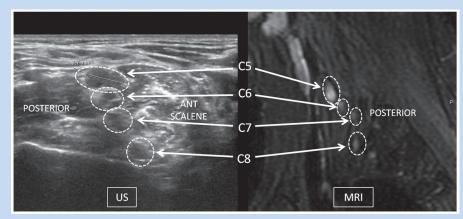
Ultrasound (US) and magnetic resonance image (MRI) of the right brachial plexus roots in a patient with upper extremity weakness after a motor vehicle accident. The US image at the interscalene triangle shows marked enlargement of the right C5 nerve root at the interscalene triangle, suspicious for a traction injury. The corresponding sagittal MRI of the right brachial plexus in the same patient shows abnormal enlargement and high signal of the C5 nerve root, confirming injury. ANT SCALENE, anterior scalene muscle.
